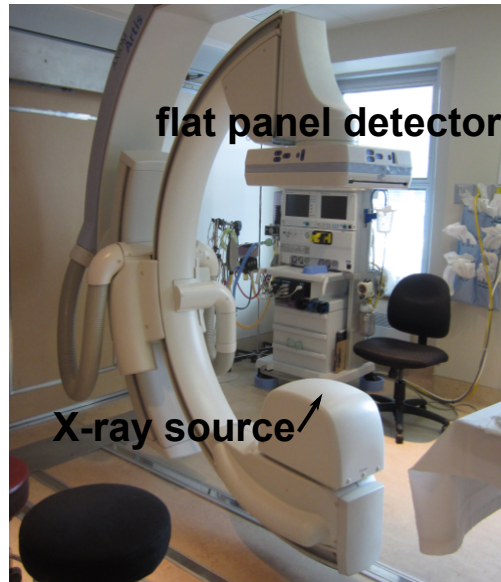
Monoplane X-ray fluoroscope.
